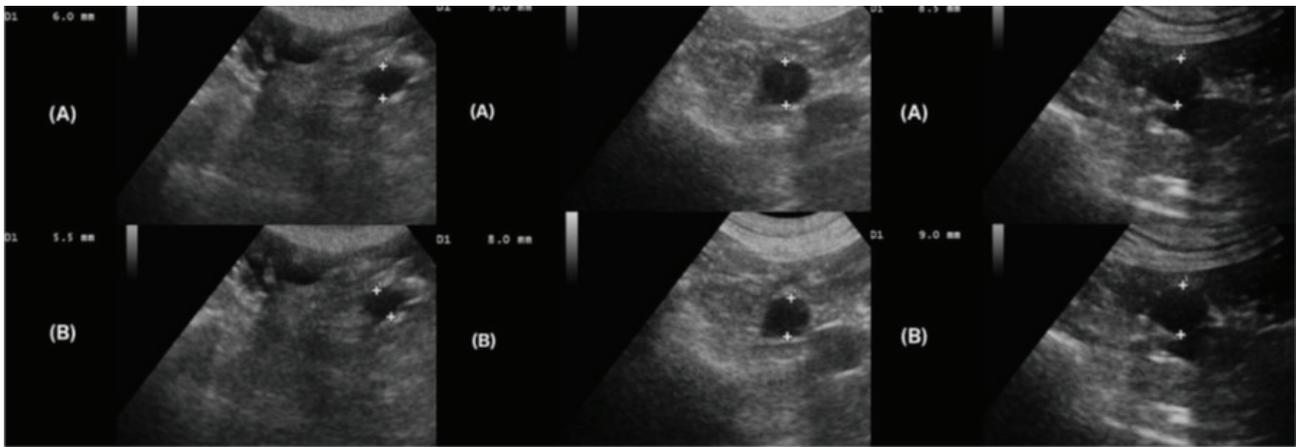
Ultrasonographic assessments for evaluating aortic elasticity. (A): Systolic diameter, (B): Diastolic diameter.
